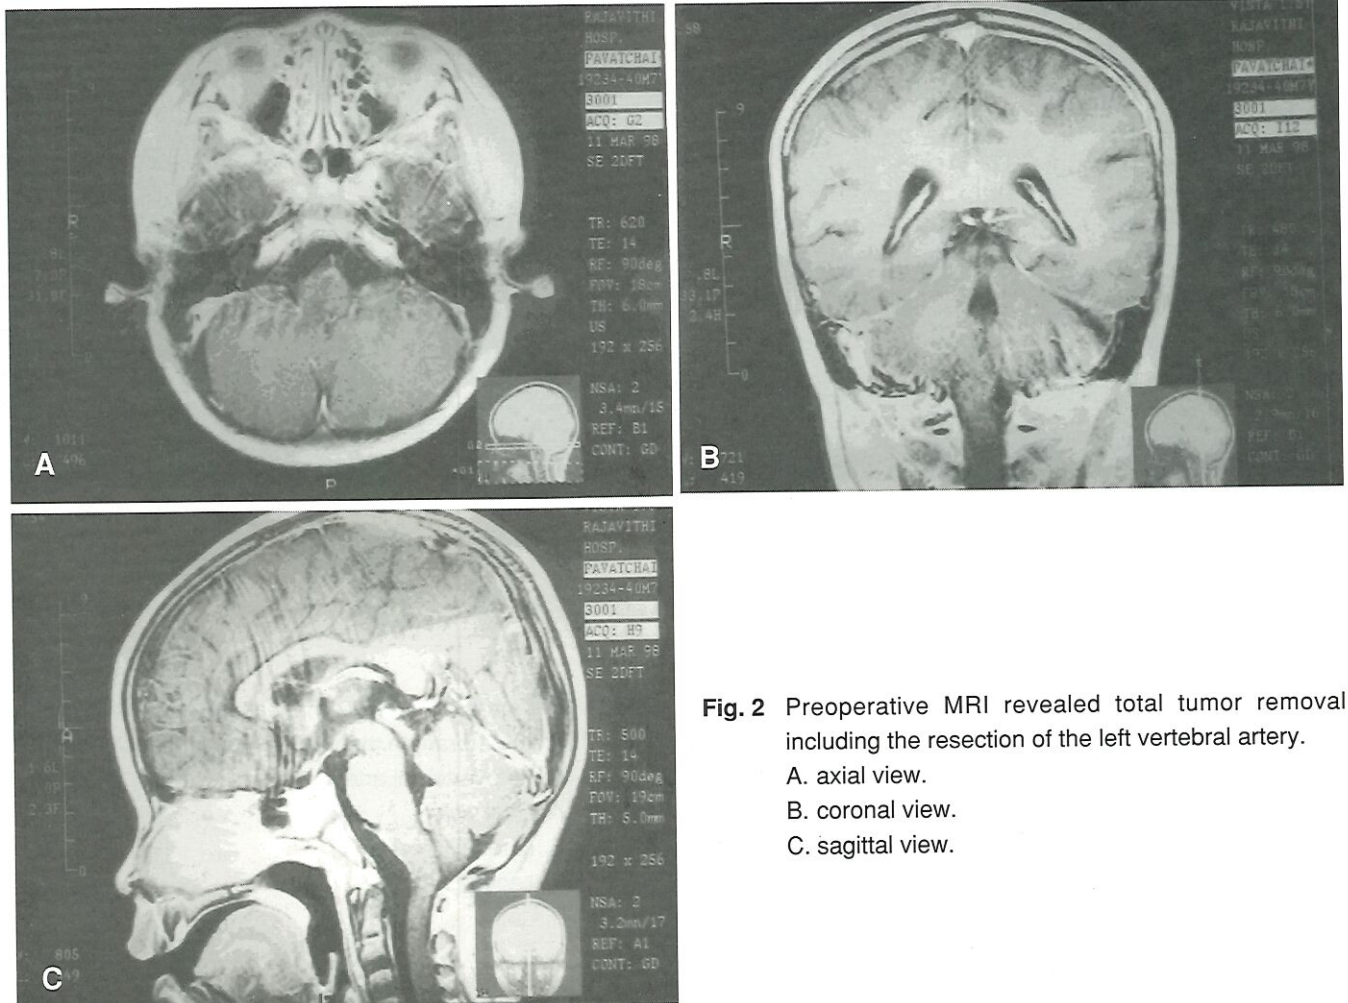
Preoperative MRI revealed total tumor removal including the resection of the left vertebral artery.
